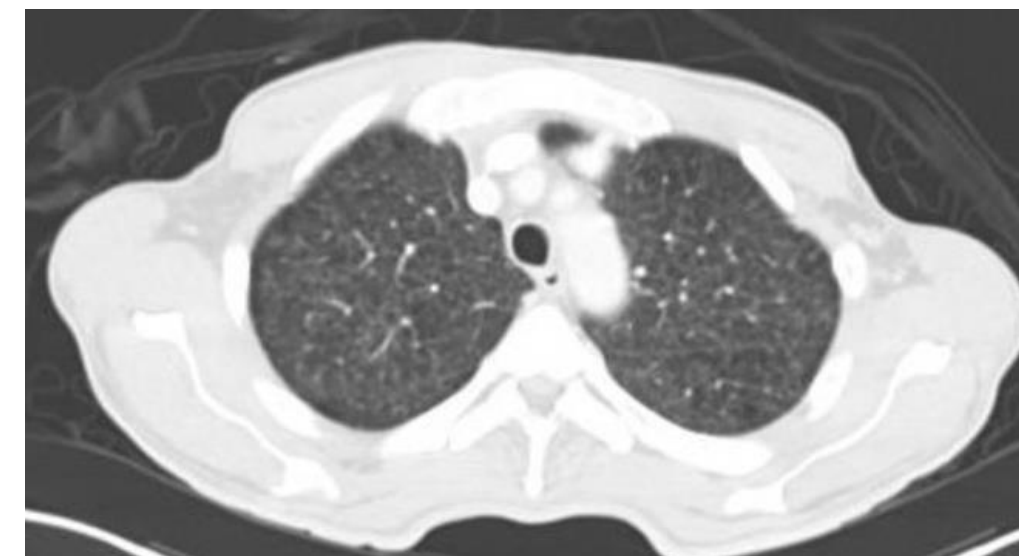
CT chest demonstrating diffuse ground glass nodules consistent with Histoplasmosis capsulatum infection.
